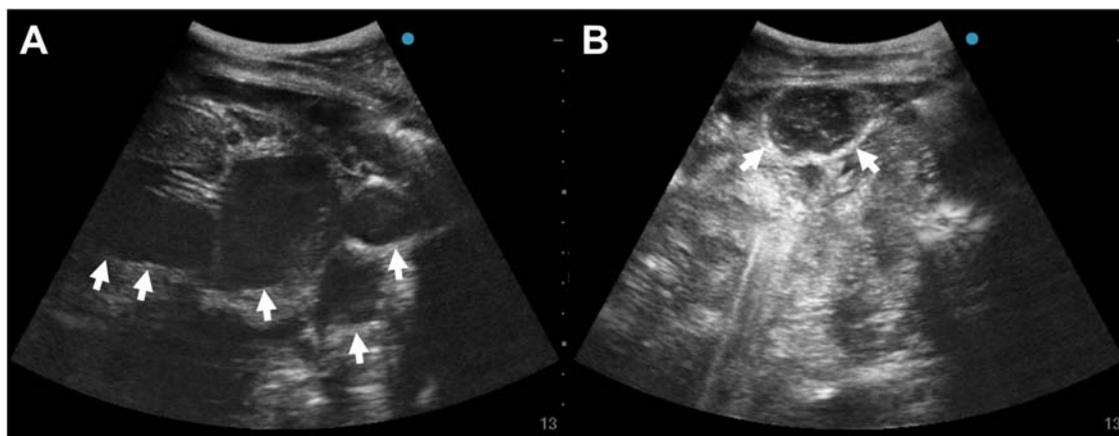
Ultrasonographic images of the thoracic cavity in this study. (A) Depicts several distended and amotile small intestinal loops (white arrows) without lung visibility in the expected anatomical location. (B) Highlights the presence of the small intestine within the thoracic cavity (white arrows). In particular, the absence of typical pleural structures and A-lines is evident. Instead, a hyperechoic heterogeneous area surrounds the small intestine, replacing the usual pulmonary parenchyma. Scan depth is indicated by the scale on the right in centimeters.
